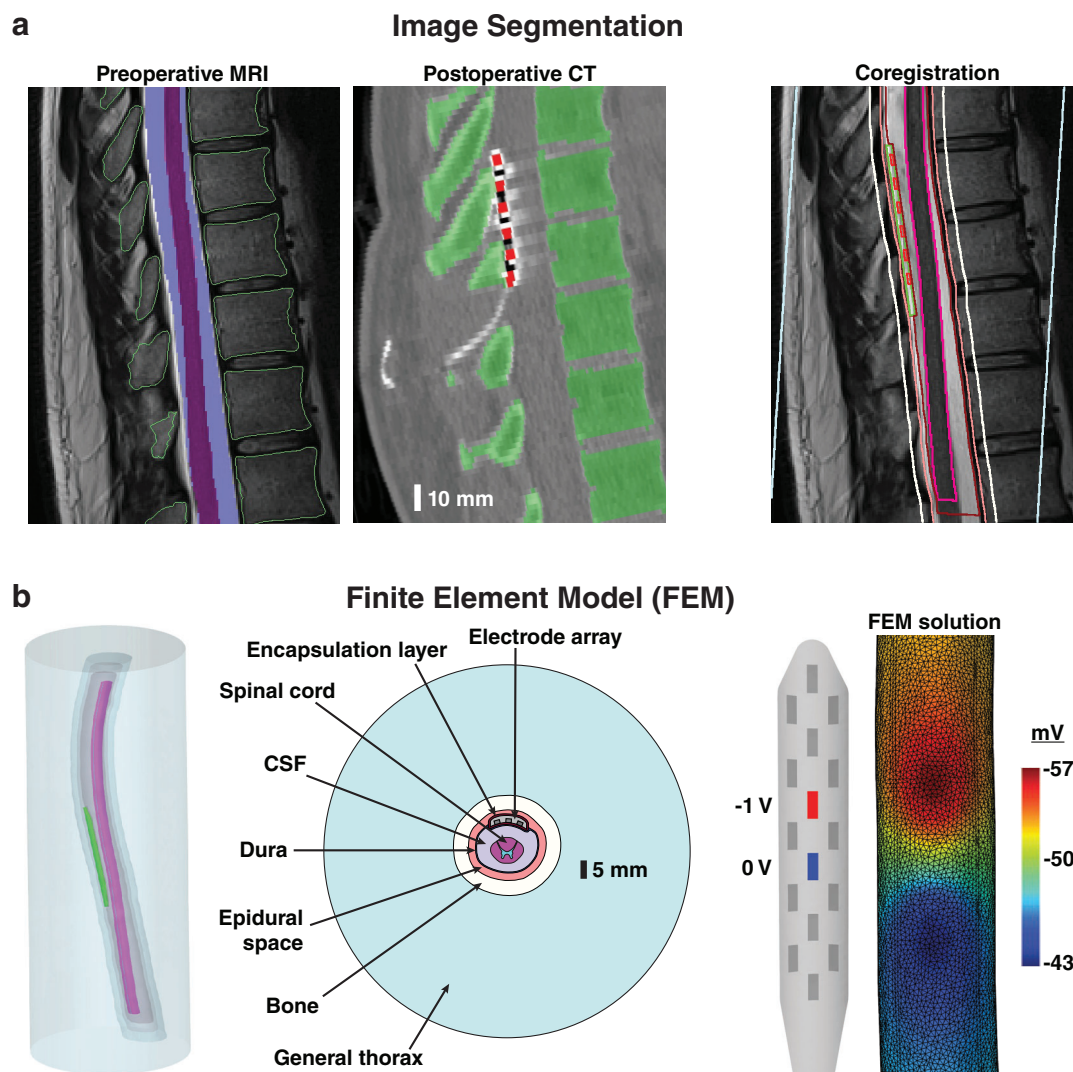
Patient-specific FEM. a. We used preoperative MRI scans to define the participant's anatomy (e.g., spinal cord, CSF, and spine) and a postoperative CT scan to define the 3D electrode locations. b. We coregistered the 3D objects segmented from the preoperative and postoperative images to define a patient-specific FEM. The figure on the top right shows outlines of the 3D FEM objects in the preoperative MRI. The figure on the bottom right shows the voltages generated on the surface of the spinal cord for a -1 V bipolar stimulus. (Note: In this figure, the electrode array and spinal cord are not drawn on the same scale.) [Color figure can be viewed at wileyonlinelibrary.com]
